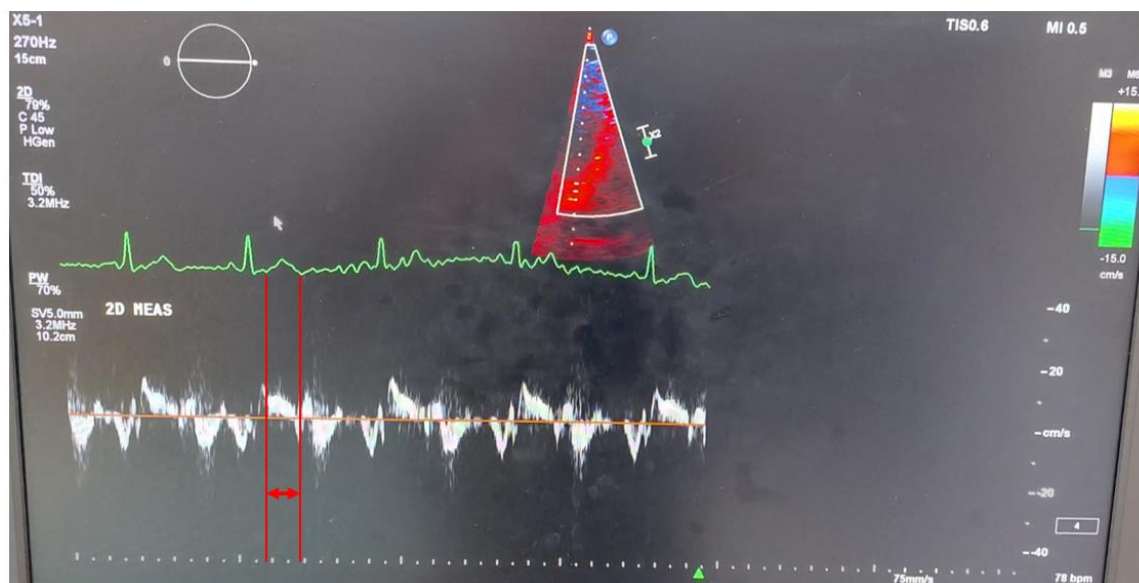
TDI ultrasound capture with ventricular ejection time highlighted (delineation with red lines).
